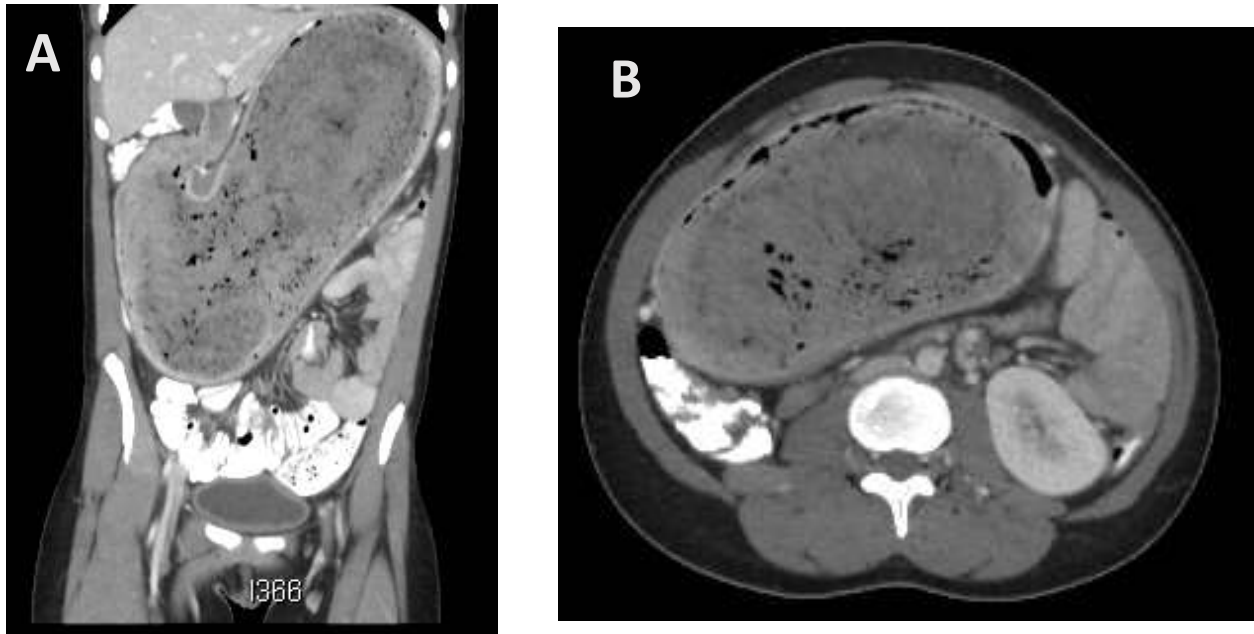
A, B: CT abdomen coronal and axial views respectively showing distended stomach with features of stomach bezoar.
